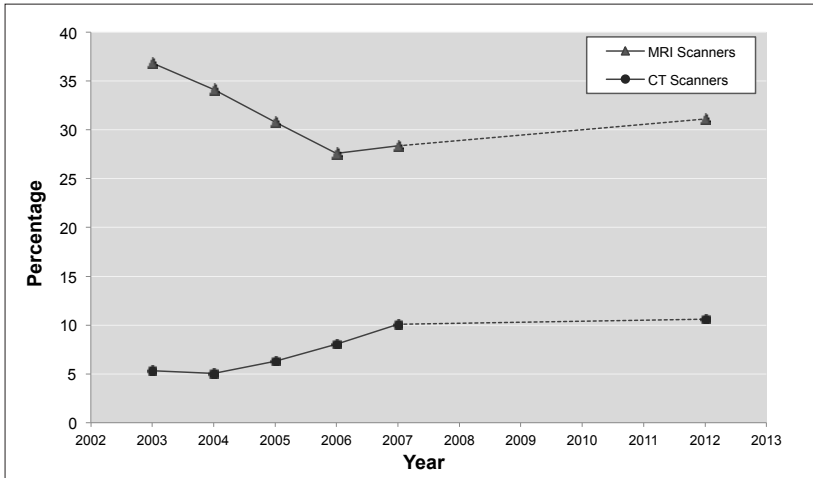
Proportion of MRI and CT scanners in free-standing facilities, 2003–2012.
